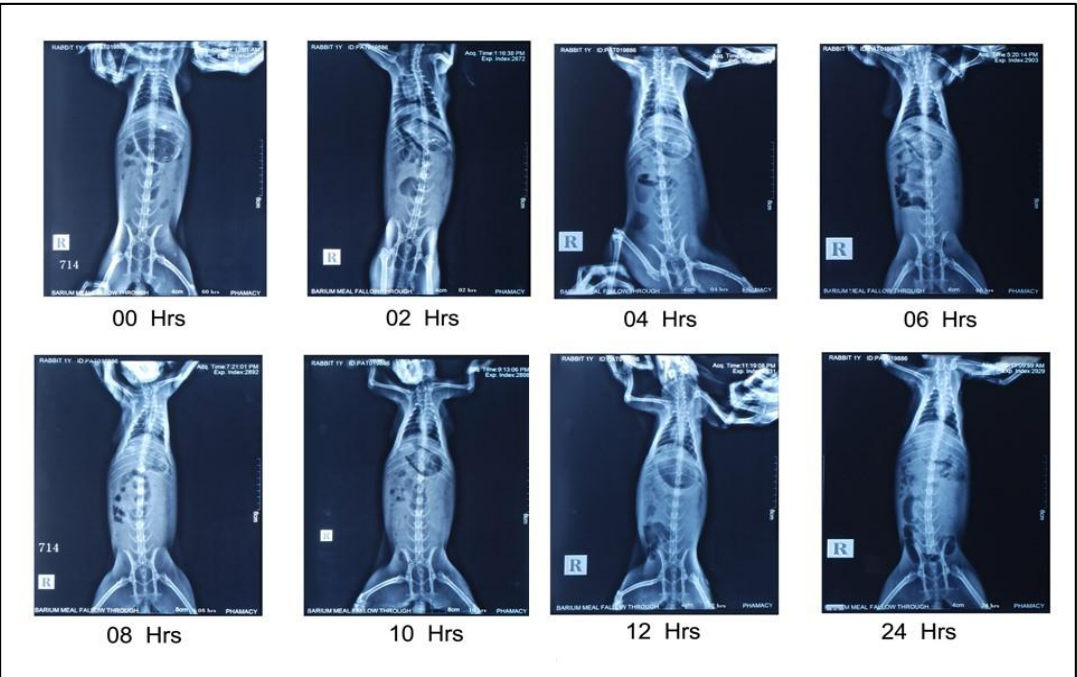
In vivo Roentgenographic study photographs
